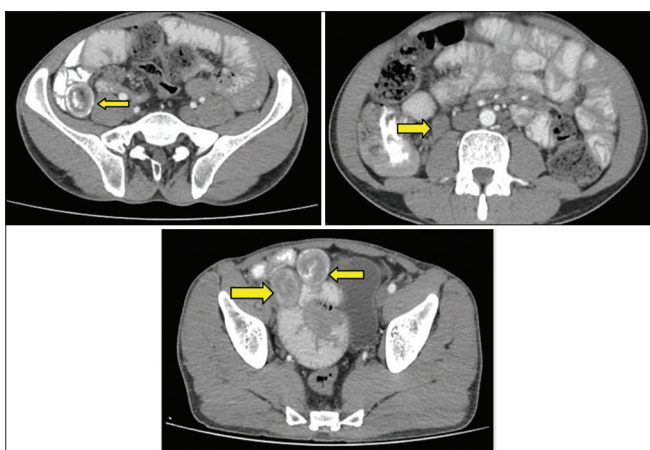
Axial sections of multidetector computed tomography enteroclysis in a 30-year-old male patient presenting with vague abdominal pain showing bowel within bowel appearance in the bowel loops visualized in the right iliac fossa and pelvis, suggestive of non-specific multifocal transient ileoileal intussusceptions and few enlarged mesenteric nodes in the right iliac fossa
